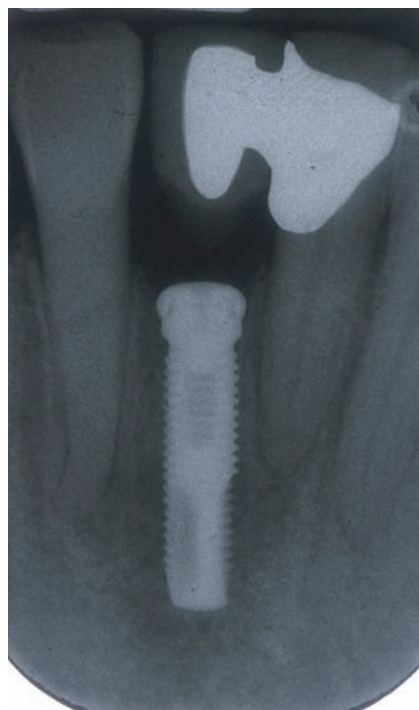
Periapical radiograph of an implant placed in the lower incisor region. There is a radiolucency associated with the apex of the implant. This was caused by overheating of the bone during the preparation of the site and presented with considerable pain.
